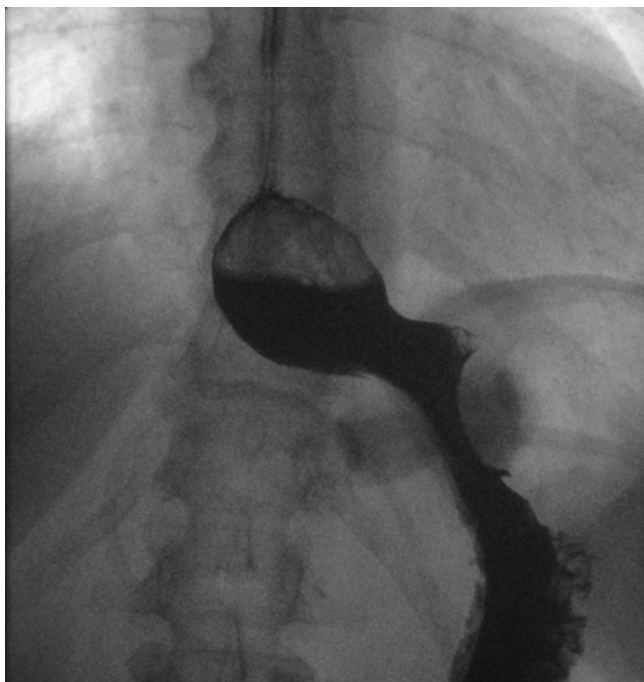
Hiatus hernia identified at X-ray contrast swallow. Note the gastric pouch dilatation above the left hemi-diaphragm
